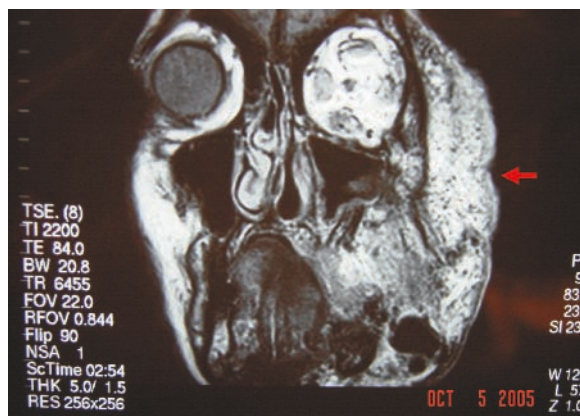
A typical MRI of an arteriovenous malformation of the left face
